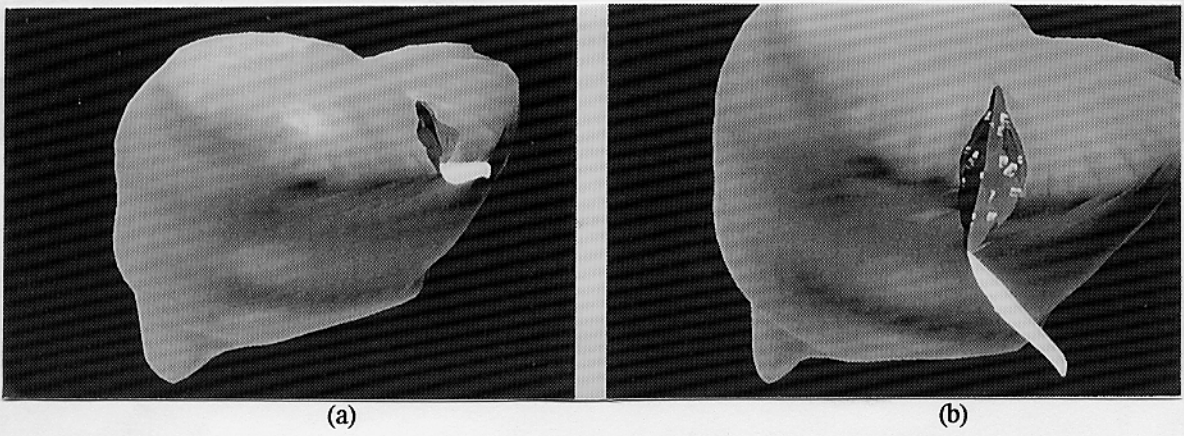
The condition of the incision on the surface of the liver model reconstructed from MRI data set
